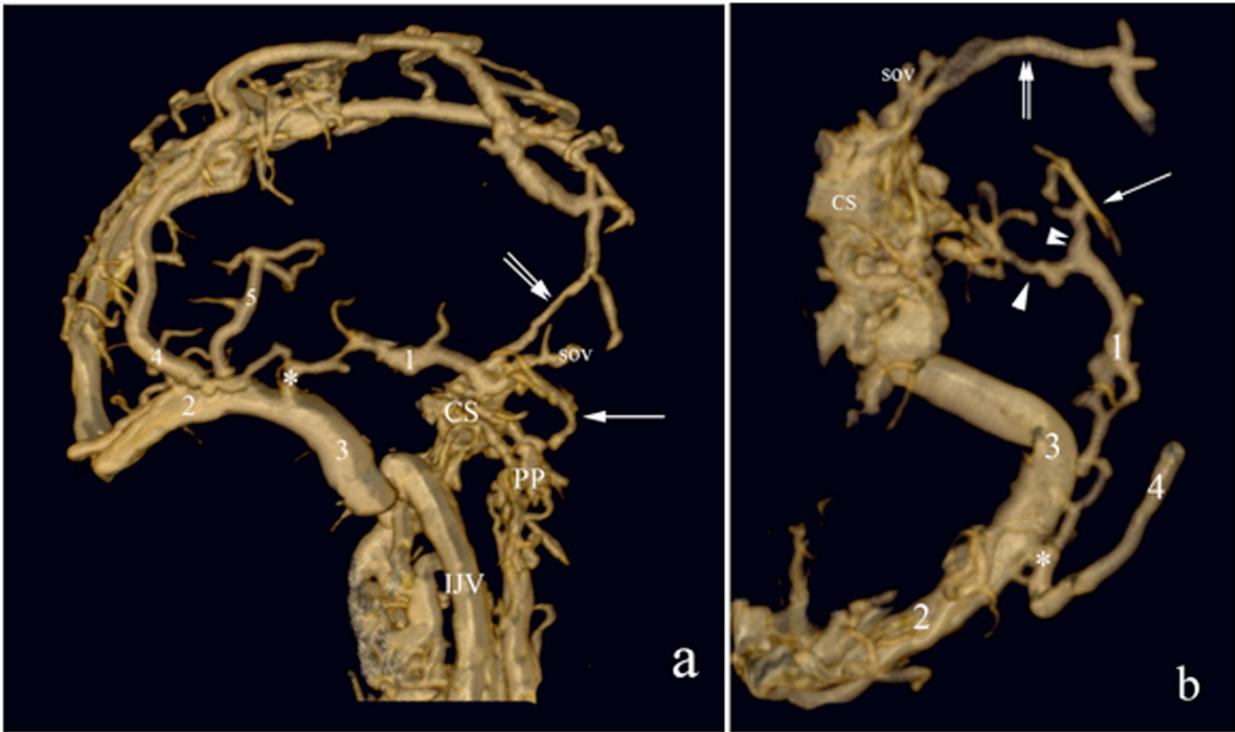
3D images after reconstruction of a CT of a corrosion cast of the cranial venous system on a Vitrea workstation (Vital Images, Minnesota, USA) (0.8 mm slices, every 0.4 mm. Philips MX 8000 IDT 16 channel-multirow detector, Philips Medical Systems, Best, The Netherlands). The cortical veins have been virtually dissected. 25a. right lateral view showing a petrosquamosal sinus (PSS) (1), the transverse sinus (2), the sigmoid sinus (3), the cavernous sinus (CS), a temporoparietal diploic vein (4), the internal jugular vein (IJV), the pterygoid plexus (PP), and the superior ophthalmic vein (sov). The PSS is connected to the transverse sinus/sigmoid sinus junction (asterisk). Close to this point, the PSS receives a posterior temporoparietal diploic vein. The single arrow points at a deep temporal vein. The double arrow represents the sphenoparietal sinus, which drained a large anterior parietal diploic vein into the cavernous sinus. 25b. superior view of the right middle cranial fossa. Same legend as 25a. The connection of the PSS with the emissary veins of the middle cranial fossa (foramen ovale) is marked by an arrowhead. The double arrowhead indicates the connection with the deep temporal vein through the postglenoid foramen (PGF). The sphenoparietal sinus (double arrow) courses over the superior ophthalmic vein (sov) and joins the anterior superior aspect of the cavernous sinus (CS).
